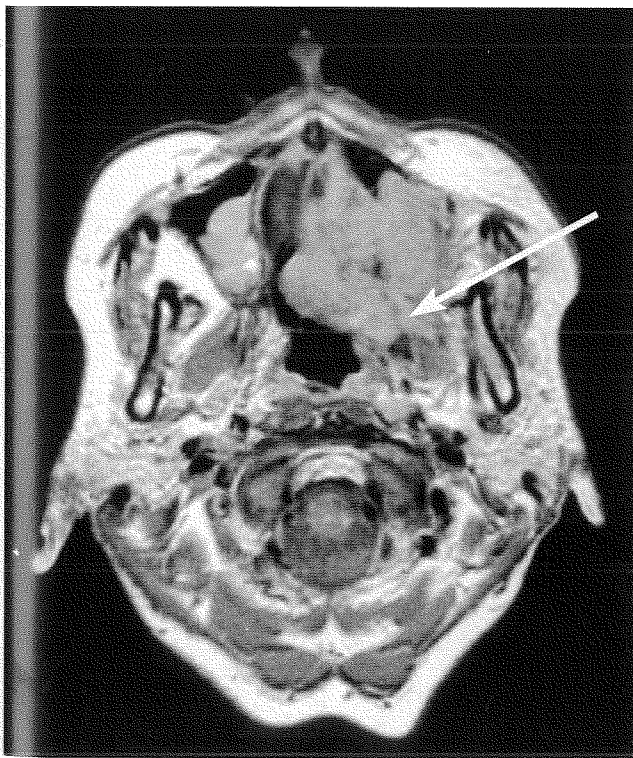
Axial CT scan of case 1 showing destruction of the posterior wall of the antrum (arrow) with infiltration of the pterygoid process and pterygoid muscles.
